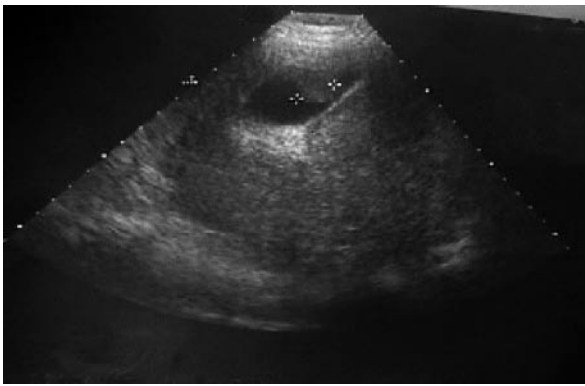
Ultrasound of melanoma of gallbladder.
